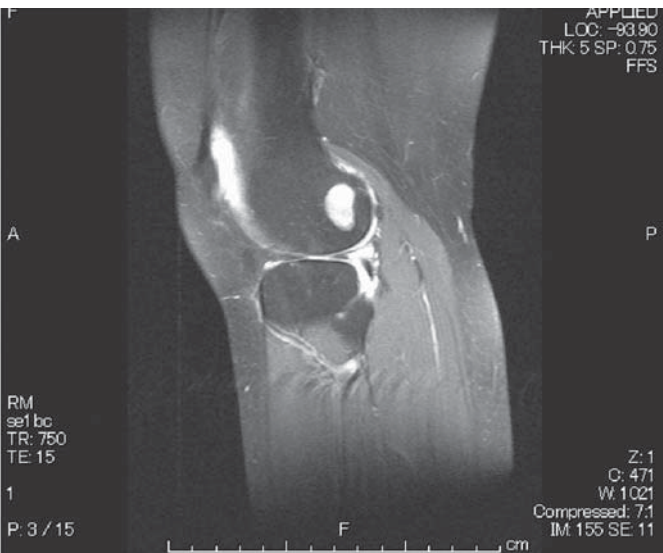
Enhanced magnetic resonance imaging with Gad demonstrates active arthritic findings such as an increased amount of joint fluid, proliferating synovialis, and erosions in her right knee joint at the baseline remarkably improved after treatment at 33 weeks
